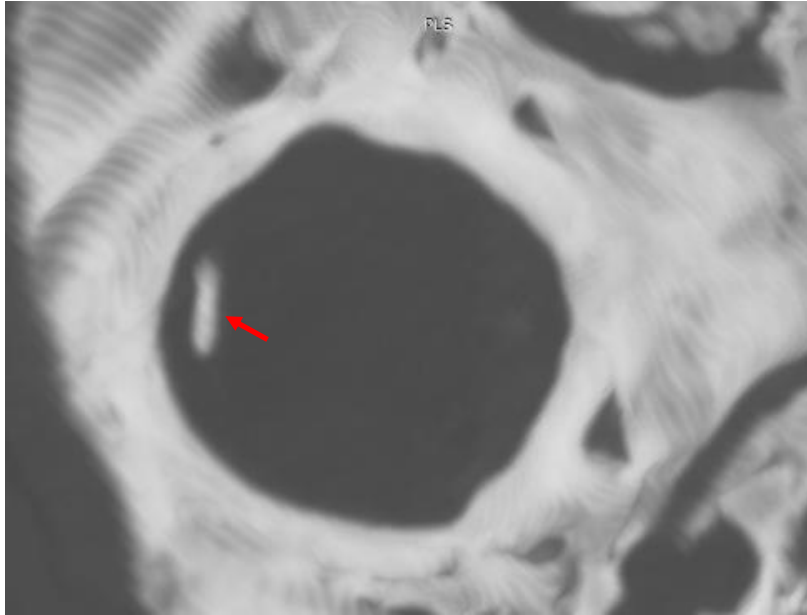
CT, axial section at a level just inside the foramen magnum. Neutral head and neck position.
